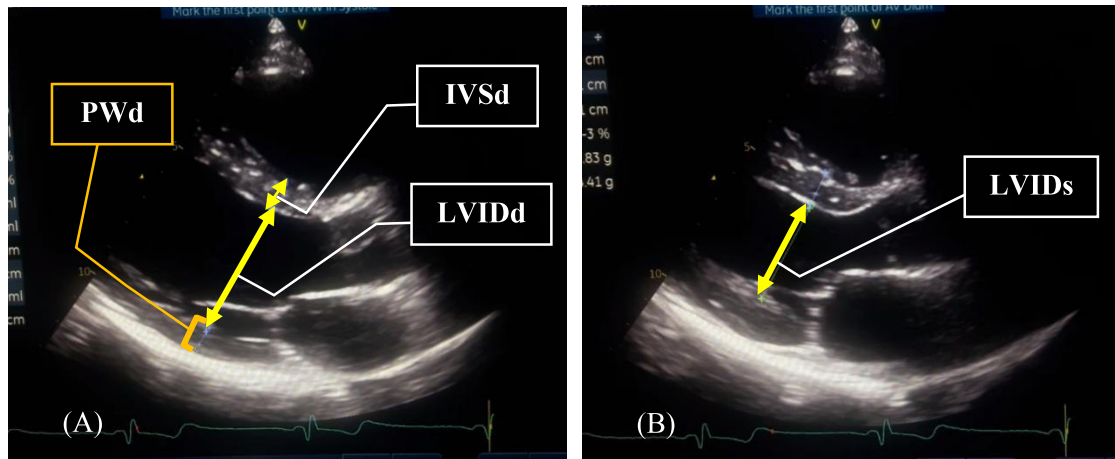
Echocardiographic Parameters. (A) Shows the LV end-diastolic measurements (i.e. LVIDd), PWd, and IVSd in the PLAX view. (B) Shows the LV end-systolic measurement (i.e. LVIDs) in the PLAX view
